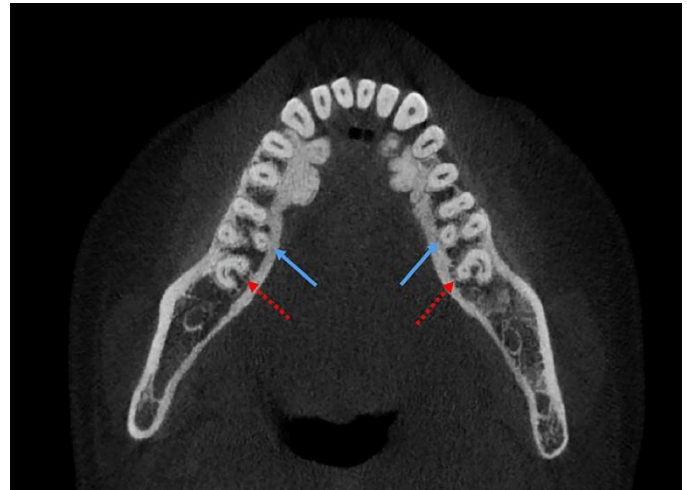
Axial view of a representative CBCT image of mandibular molars with a fused root with a C-shaped canal (dotted red arrows) and the additional root of a three-rooted molar (blue arrows). Bilateral three-rooted first molars and C-shaped canals were seen in the second molars
